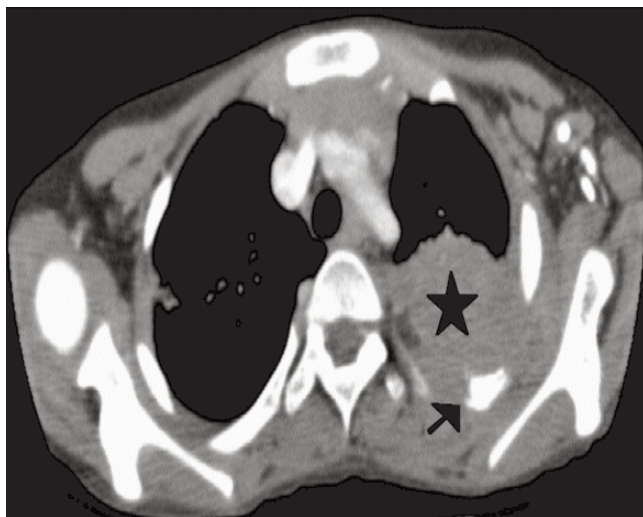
CT - chest showing left upper lobe consolidation (star) and erosion of third rib (arrow).
